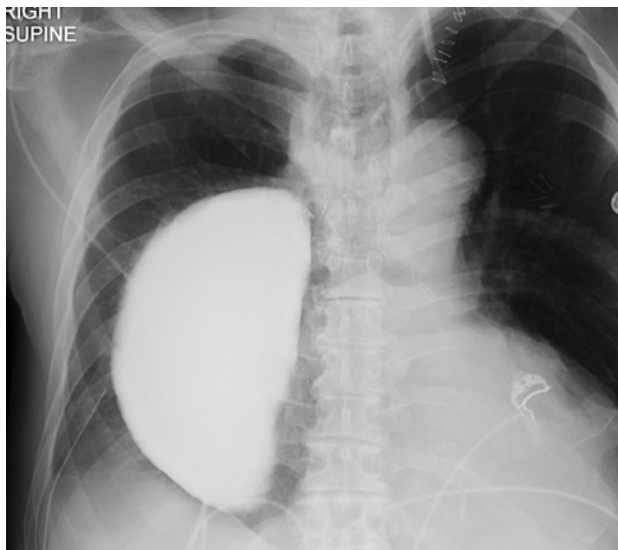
Upper gastrointestinal radiograph of the stomach in the chest.
